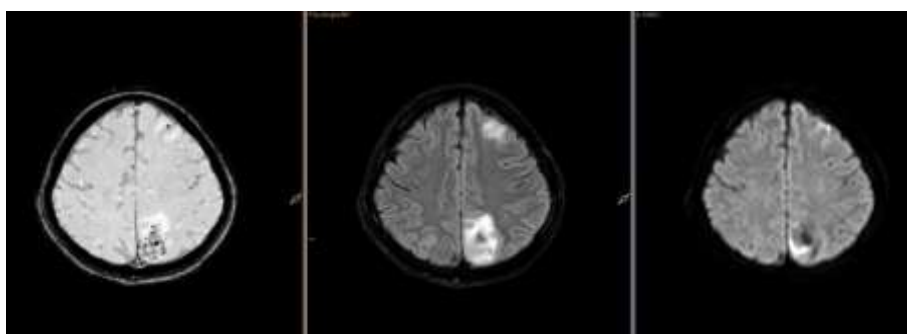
Axial MRI images (SWI, FLAIR and DWI) show a focal haemorrhagic lesion in the left parasagittal parietal cortex with surrounding cortical–subcortical edema, in keeping with haemorrhagic changes in posterior reversible encephalopathy syndrome.
